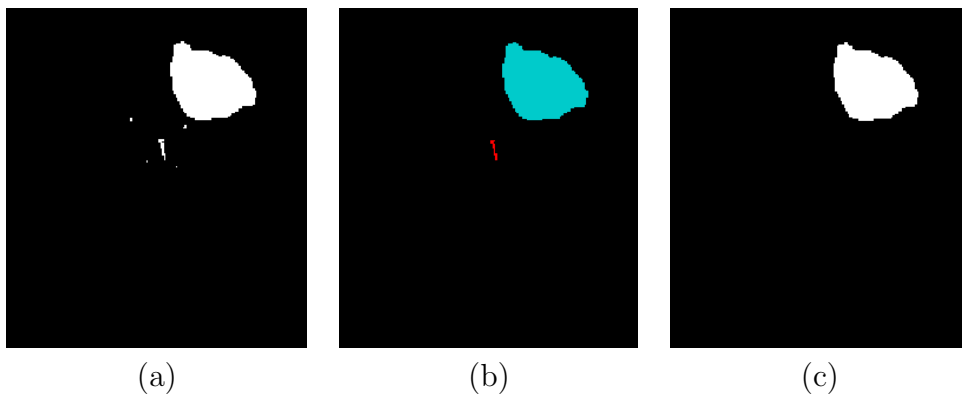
Tumor detection result for a non-enhanced tumor in a FLAIR image (Figure 4.9). (a) One axial slice of the selected tumor class. (b) Connected components of the tumor class (the tumor is the largest component). (c) Detected tumor.
